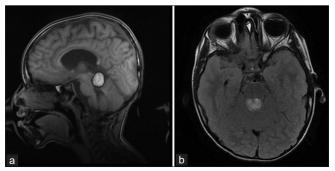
Magnetic resonance imaging of the brain demonstrating the quadrigeminal plate lipoma ($2.5 \text{ cm} \times 1.9 \text{ cm} \times 1.6 \text{ cm}$) in (a) T1 sagittal and (b) T1 axial.
